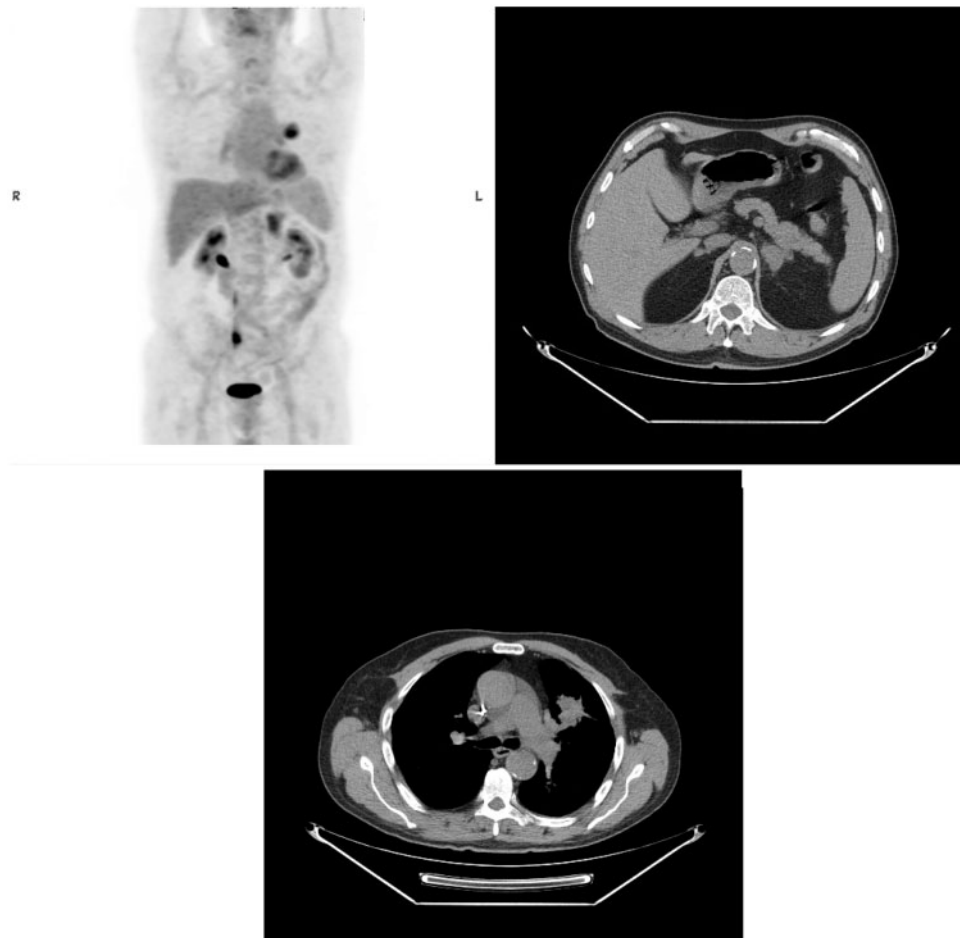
Positron emission tomography/computed tomography scan demonstrates a hypermetabolic mass in the left upper lobe (2.5 × 4.2 cm), increased from 3.6 × 3.9 cm 4 months previously. A hypermetabolic mass measuring 2.7 × 4.2 cm is also visible on the left adrenal gland.
